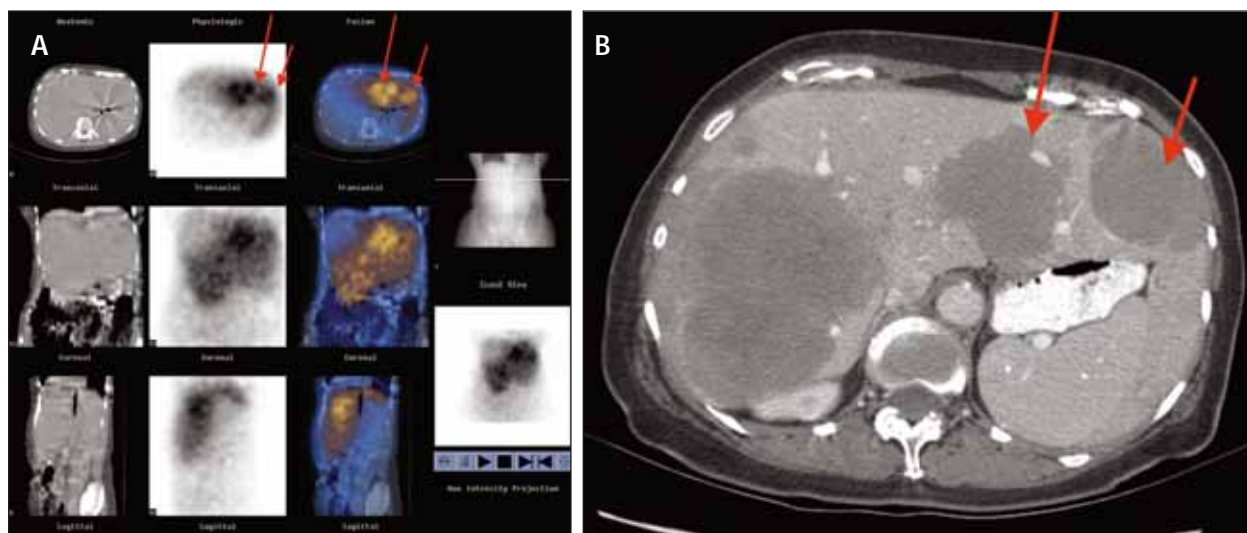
A 68-year-old woman with hepatic metastatic carcinoid malignancy. Thirty-five mCi of Y 90 microspheres was delivered via the left hepatic artery (A). SPECT-CT fusion Bremsstrahlung scans 36 hours after the treatment demonstrate preferential deposition within the metastases (arrows) that are more accurately depicted on the contrast-enhanced axial CT scan (B).
